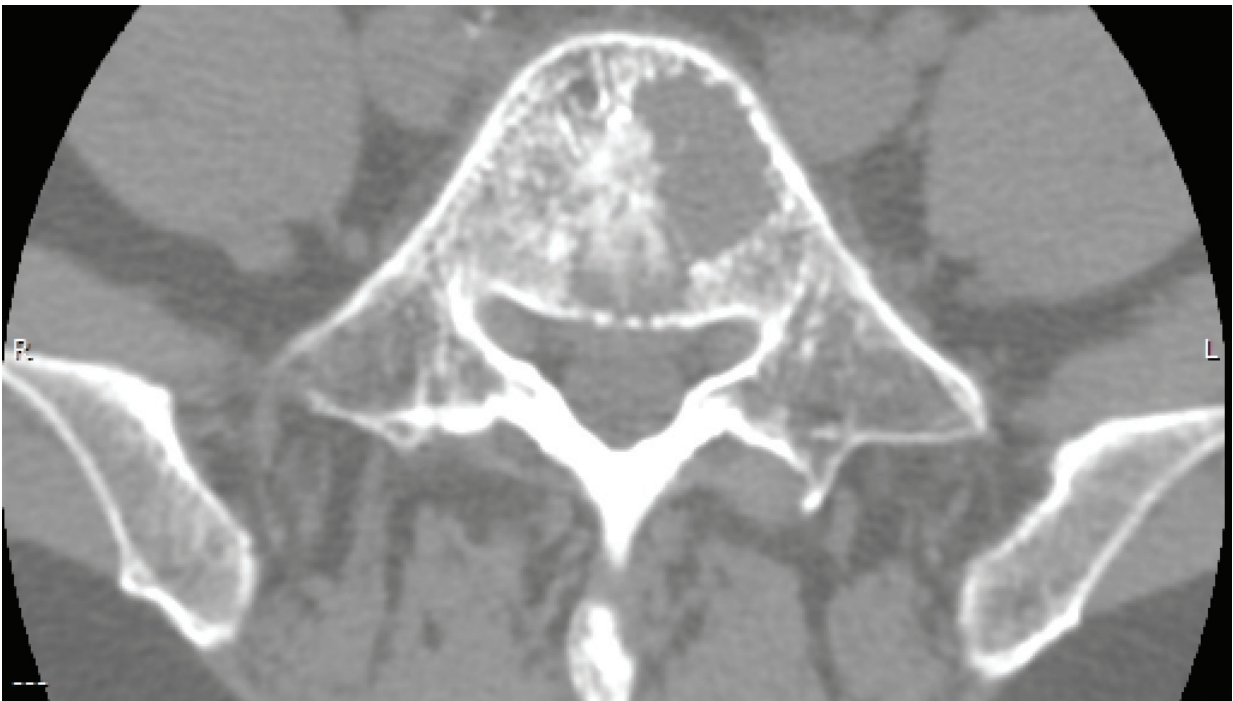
Pre-procedural CT showing a predominantly osteolytic bone lesion in the soma of L5, with diameters of 27x19mm.
